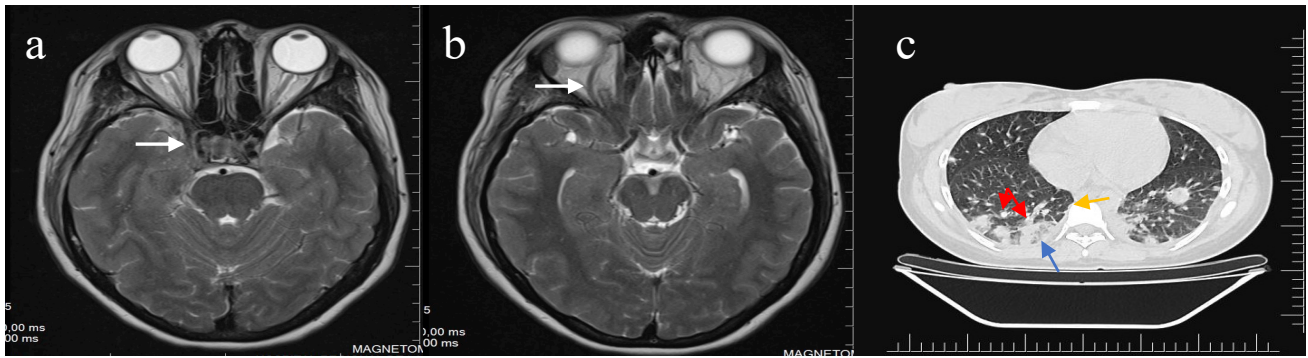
shows a) MRI without contrast in axial slices at the level of the middle fossa, the white arrow shows an increase in the diameter of the right cavernous sinus, which also shows signal alteration predominantly hyperintense on T2 around of the ICA. b) The white arrow shows an increased flow at the level of the superior ophthalmic artery. c) Show images of a Lung CT scan without contrast in axial slices in the parenchyma window. the arrow blue shows multiple consolidative processes at the peripheral level that predominate on the right side, additionally, we can observe multiple adjacent noddles, which converge whit the consolidative zones (red arrow). the orange arrow shows little reactive adenopathies at the level lateral of the trachea.
